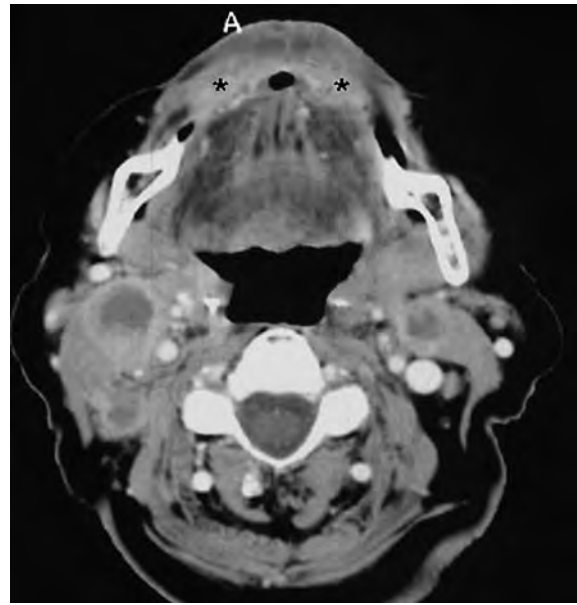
CT in a 55-year-old pipe-smoking male with a squamous cell carcinoma of the lower lip. The contrast-enhancing mass is on both sides of the midline, the adjacent soft tissues are edematously swollen. In level II there are bilateral lymph node metastases with central necrosis
